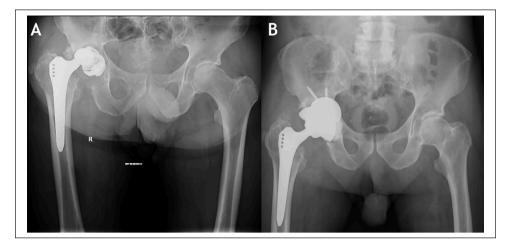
Radiological analysis in a clinical setting of aseptic loosening. A: preoperative x-ray showing massive medial and superior acetabular bone loss. B: I-year follow-up showing optimal osseointegration and hip biomechanics restoration.
